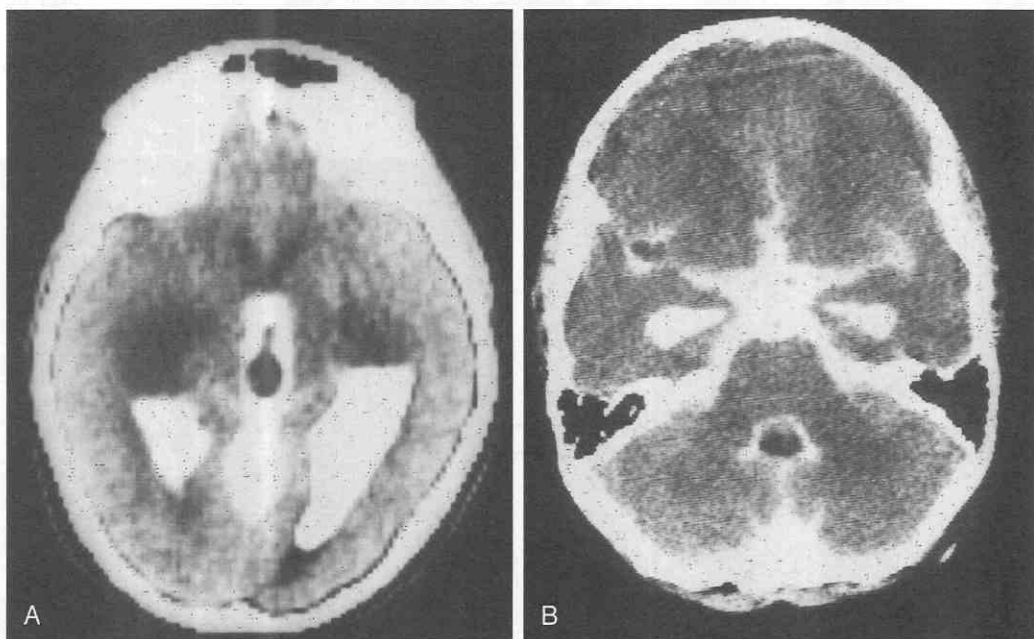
Cyst mobility in cysticercosis. *A*, Initial CT ventriculogram shows a cyst in the third ventricle. *B*, The cyst moved into the fourth ventricle on the metrizamide CT ventriculogram performed on the morning of surgery. (From Zee C, et al: Intraventricular cysticercal cysts: Further neuroradiologic observations and neurosurgical implications. *AJNR Am J Neuroradiol* 5:727-730, 1984. Copyright American Society of Neuroradiology, 1984.)
